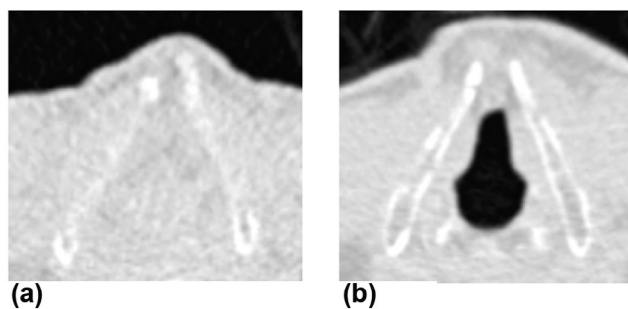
Portions of a computed tomography (CT) slice showing a closed (a) and open (b) glottis. The complete closure of the glottis ensures airways closure.
